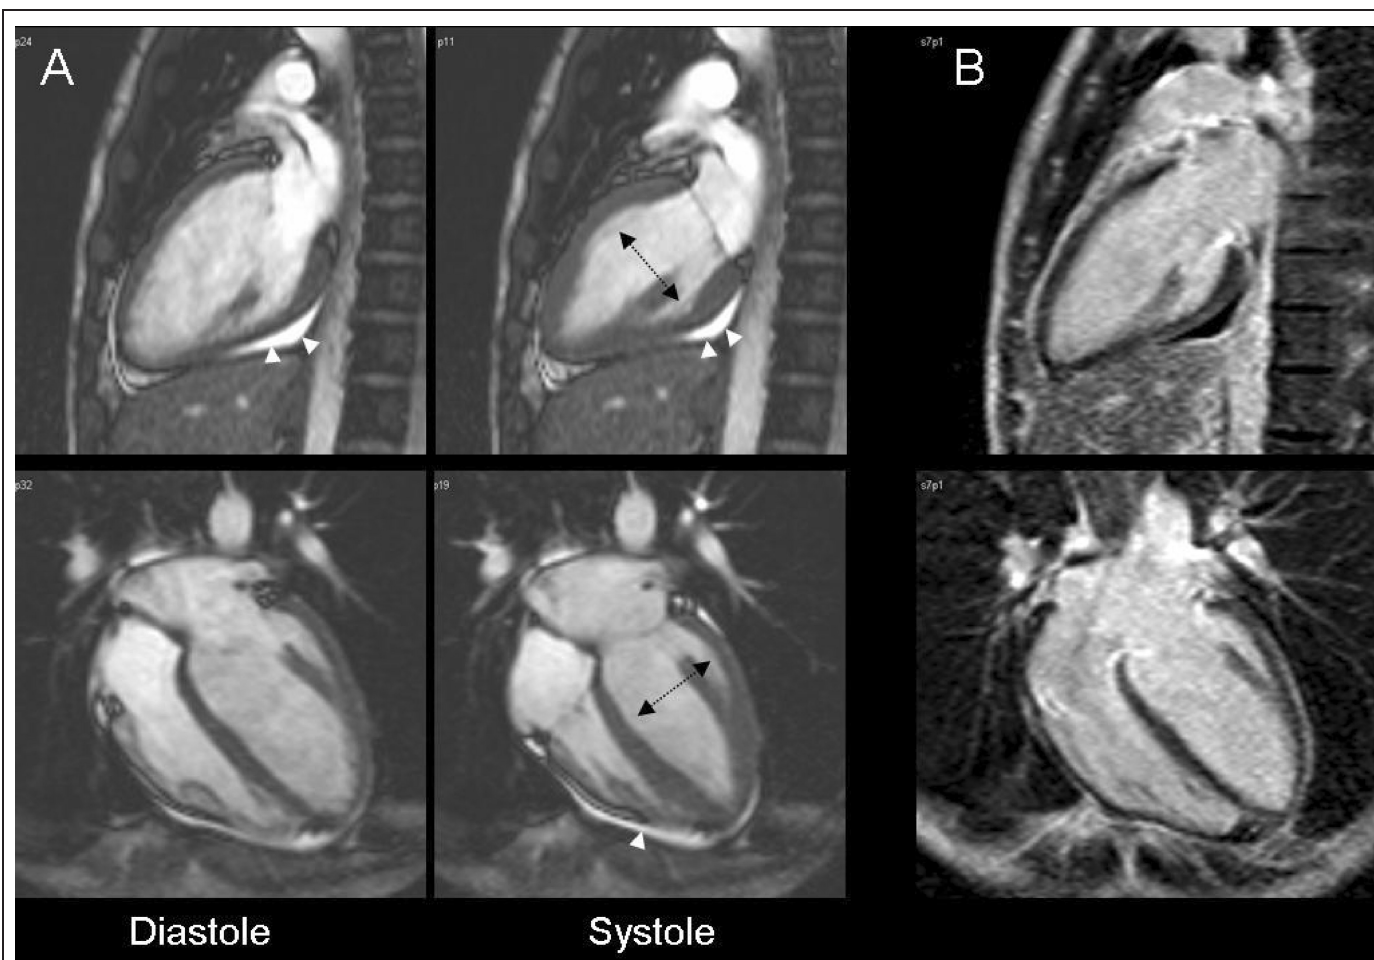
Vertical (top) and horizontal (bottom) left ventricular long-axis views. A, Cine-MR images showing akinesia of the mid-ventricular segments (arrows) with preserved motion in the apical region. A mild posterior pericardial effusion (arrow heads) is also seen. B, Late gadolinium images show no enhancement, this excluding the presence of myocardial necrosis or focal fibrosis.
